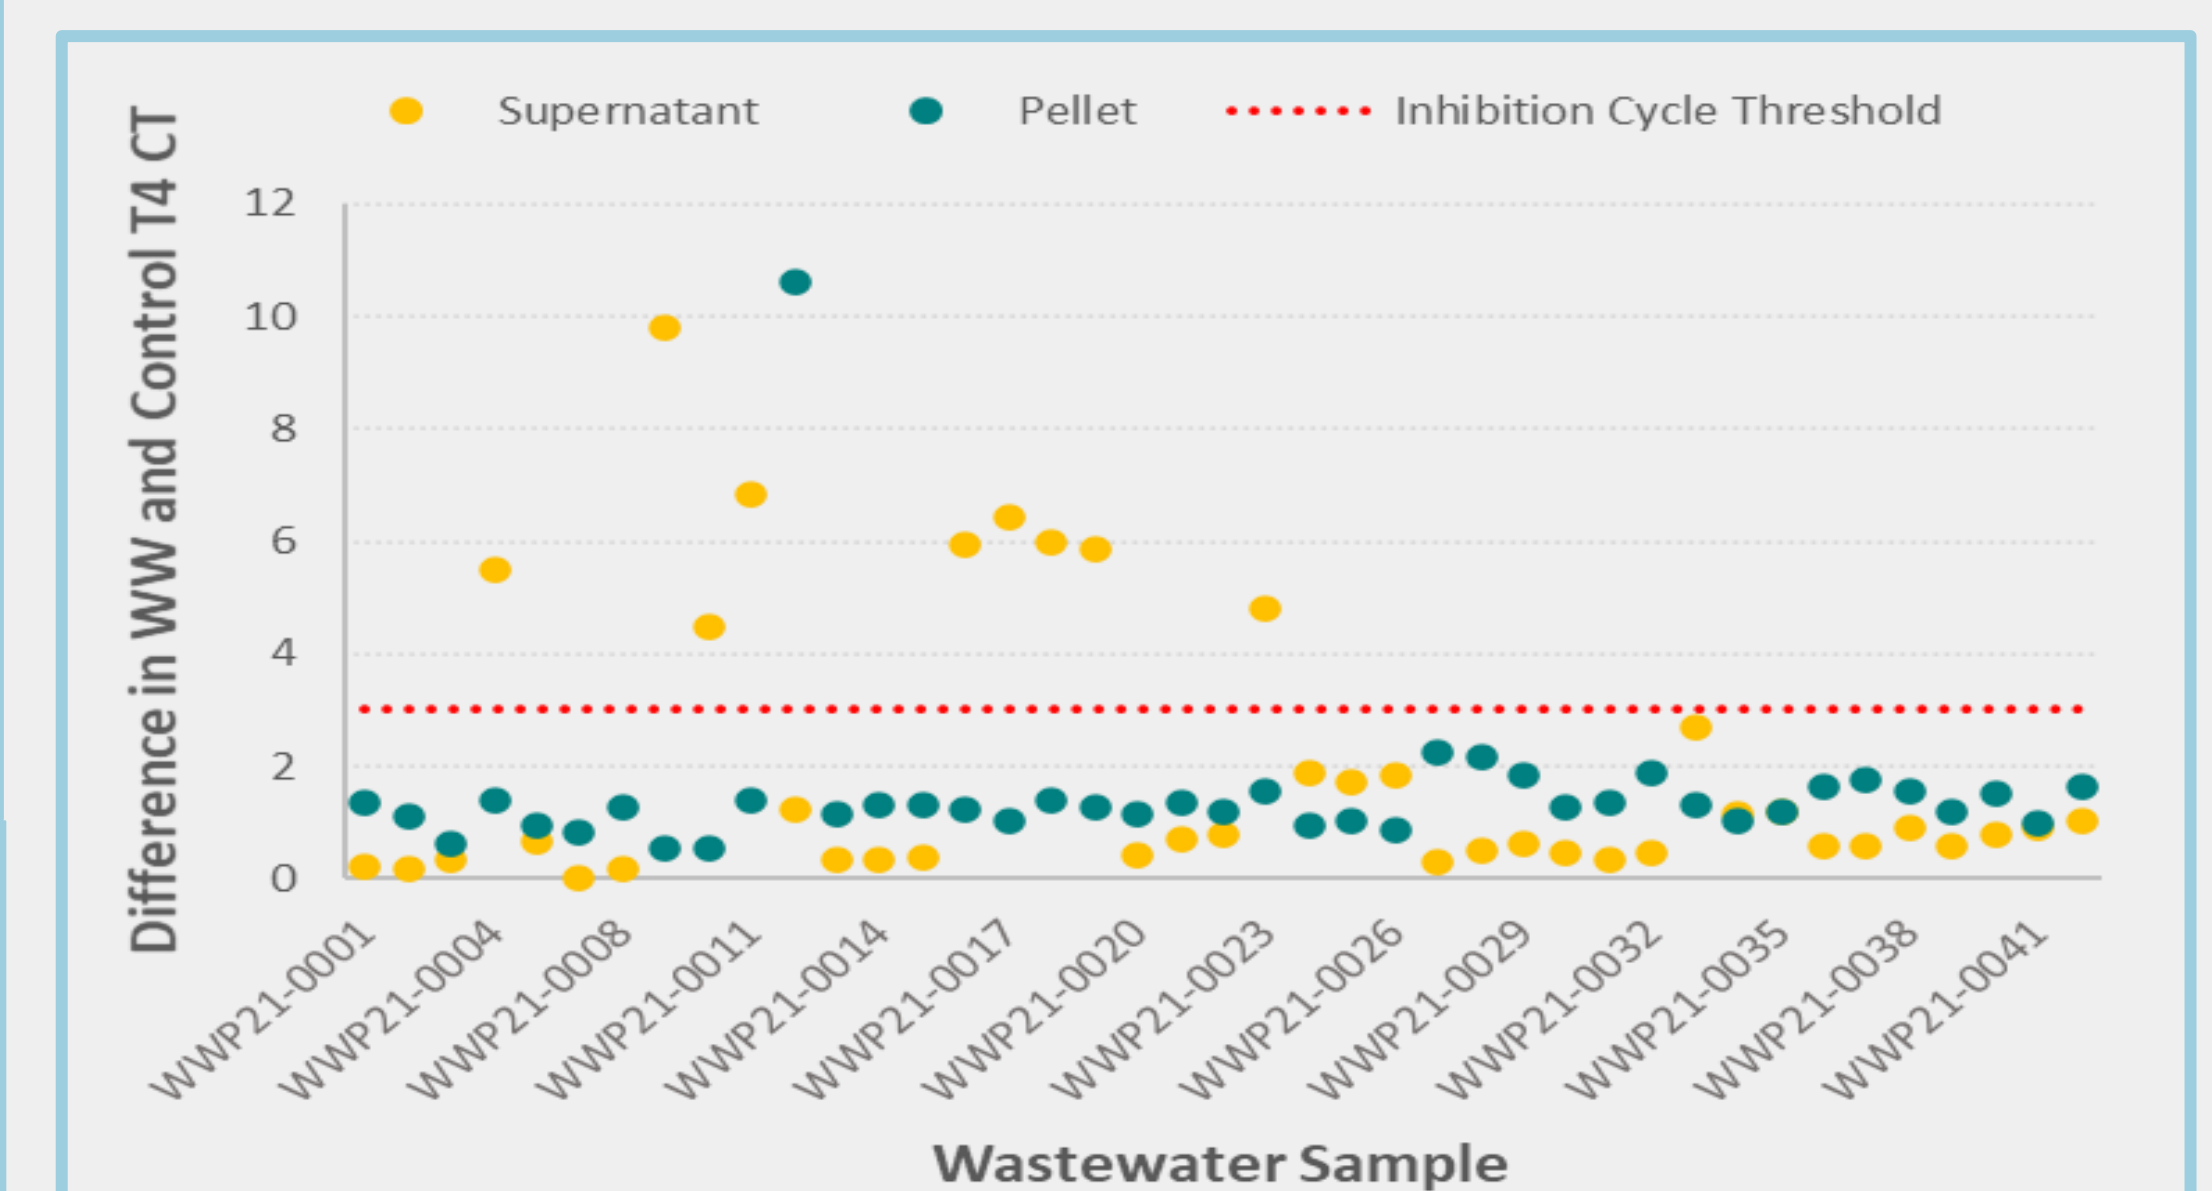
Difference in WW and extraction control T4 CT values. WW and controls were spiked with Bacteriophage T4 DNA prior to DNA extraction. A CT difference greater than 3 (red line) between WW and control indicates inhibition. All samples above the inhibition CT were processed prior to the finalization of the protocol and therefore do not indicate inhibition.
